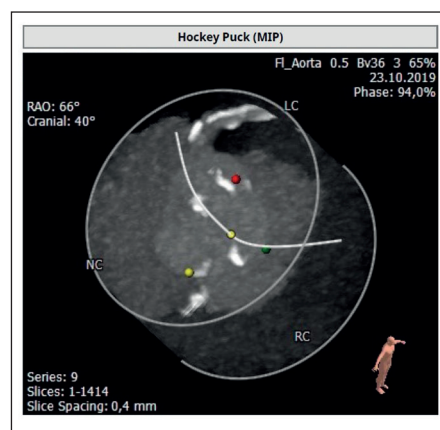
Low calcification grade of the native aortic valve by TAVI-CT.
